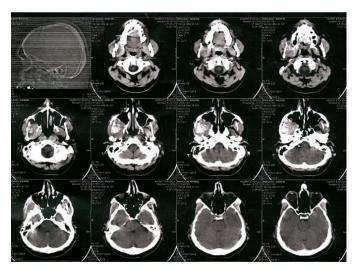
CT scan showed soft tissue mass in right masticator space extending into sphenopalatine foramen, which contains several rings and crescents calcification as well as ramus erosion of right mandible and RT sphenoid bone and pressure impact at the posterior wall of right maxillary sinuses and Posterior wall maxillary sinus bowed anteriorly. It could suggest a neoplastic lesion like Ossifying fibroma or chondrosarcoma. Opacity was observed in right maxillary sinuses.
